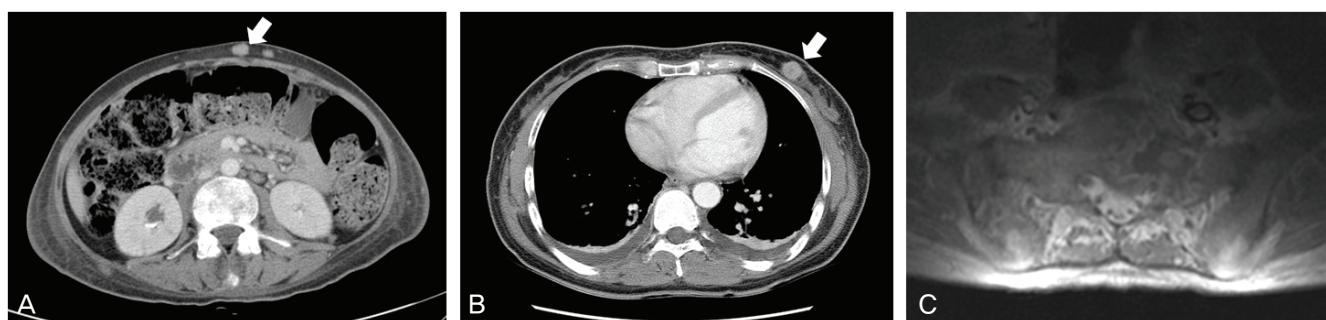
Computed tomography and magnetic resonance imaging findings of 5 months after operation. (A) Abdomen: several enlarged abdominal para-aortic lymph nodes and multiple metastatic subcutaneous nodules (arrow). (B) Chest: bilateral enhancing nodular pleural thickening and subcutaneous nodule (arrow). (C) Spine: heterogenous enhancement of sacrum and iliac bone suggesting diffuse metastasis.
